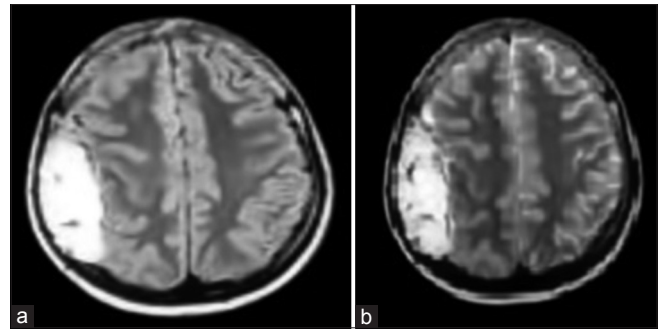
(a) Magnetic resonance imaging of brain T1-weighted images showing hyperintense extra-axial lesion in the right parietal region. (b) Magnetic resonance imaging of brain T2-weighted images showing hyperintense extra-axial lesion in the right parietal region
